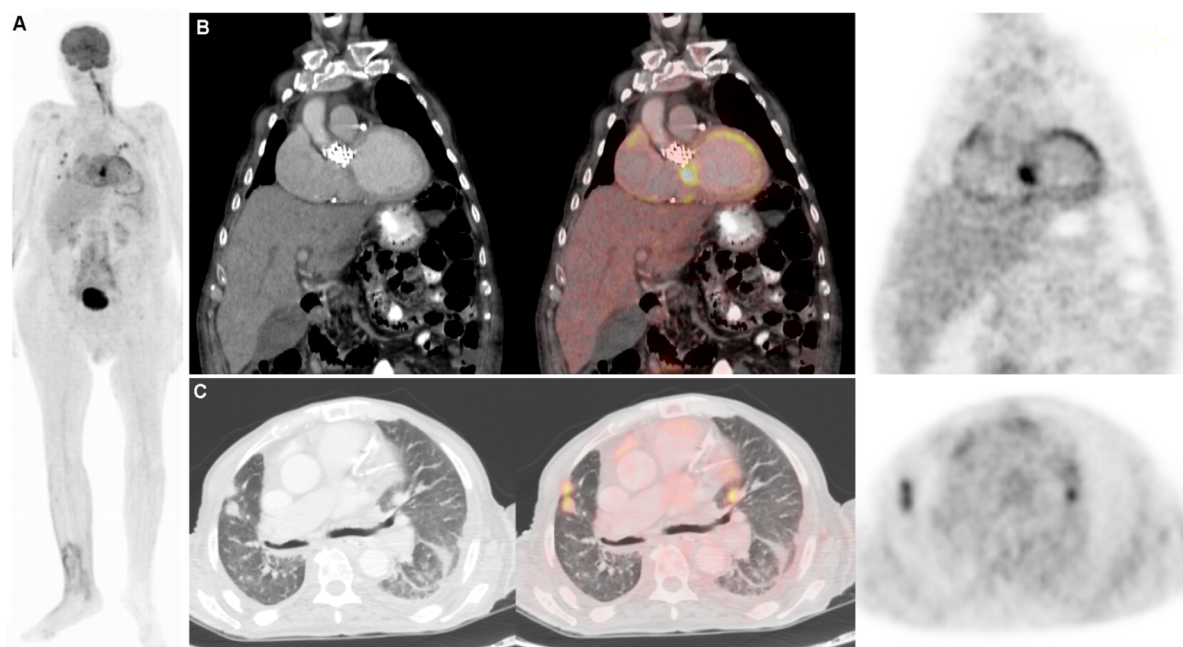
Patient 7. a Anterior view maximum intensity projection showing increased pathological FDG uptake in the mediastinum, lungs, and in cutaneous and subcutaneous tissue in the right ankle and distal shin, SUVmax 4.1. In addition, increased FDG uptake of low intensity was observed in multiple splenic infarctions, SUVmax 3.3. b Coronal view CT, FDG-PET/CT fusion, and maximum intensity projection images showing increased pathological
